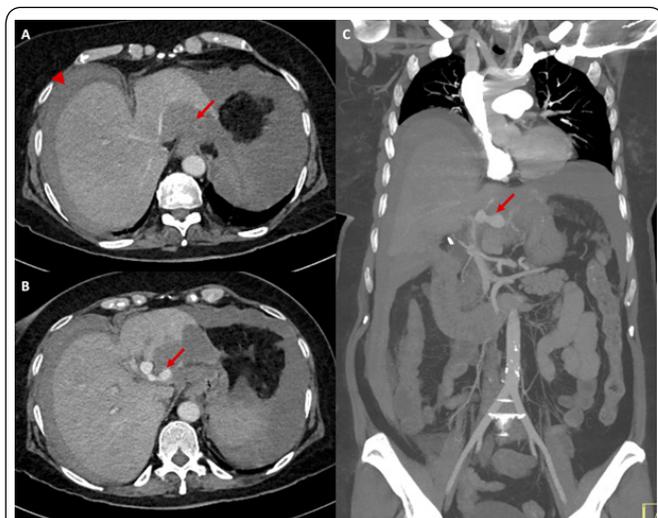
Axial slices and a coronal reformat of an abdominal CT scan performed with IV contrast. (A) An arrowhead demonstrates diffuse large volume hemoperitoneum and an arrow demonstrates active extravasation. (B) An arrow demonstrates the left hepatic artery with two areas of focal dilatation, in a dumbbell shape. (C) An arrow demonstrates the variant left hepatic artery arising from the gastric artery, with a dumbbell shaped aneurysm.
